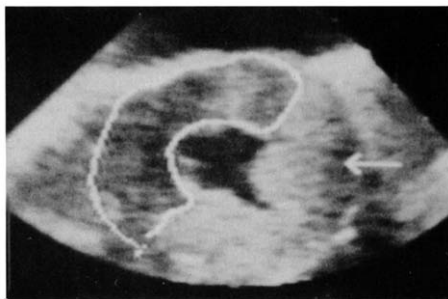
Diastolic frame of the echocardiographic short-axis view of the left ventricle at mid-papillary muscle level. The planimetry-determined area constitutes the area of relative underperfusion observed after the administration of dipyridamole and in the presence of stenosis of the left anterior descending coronary artery. The arrow points to an area of lateral dropout.
